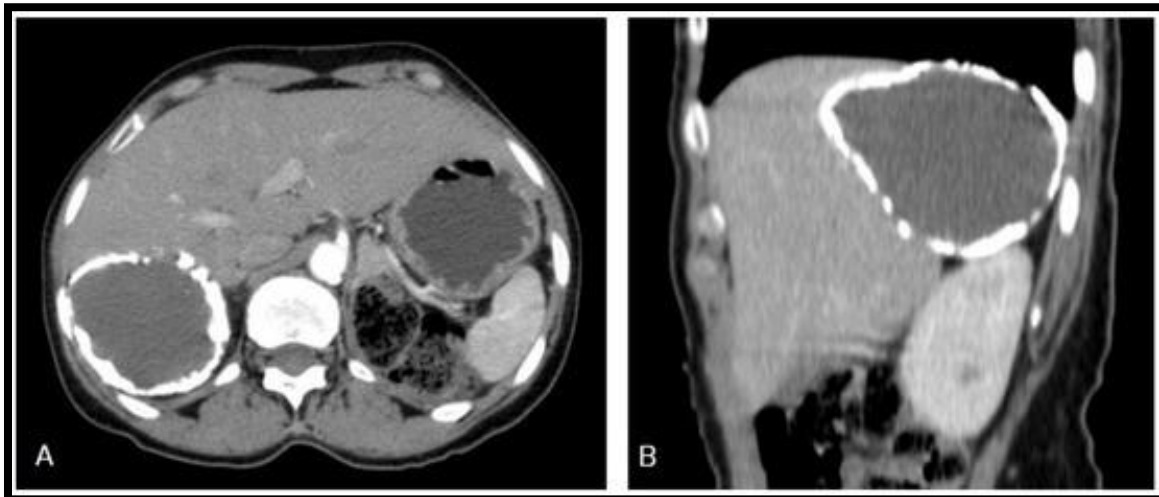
Show the axial (A) and sagittal (B) CT images of a 56-year-old female presenting with right upper quadrant pain, showing a well-circumscribed unilocular cystic.
